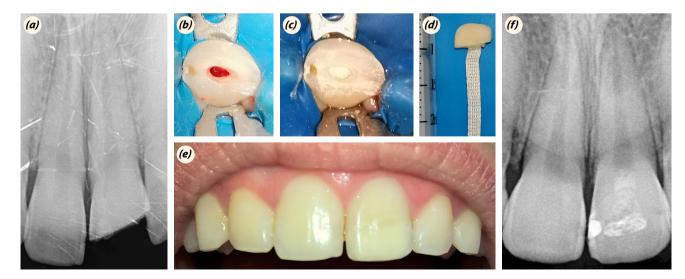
(a) Pre-op radiograph. (b) Coronal pulp tissue was removed. (c) MTA was placed after hemostasis. (d) Ribbond was bonded to the fractured fragment. (e) Post-op buccal appearance (f) post-op radiograph.
